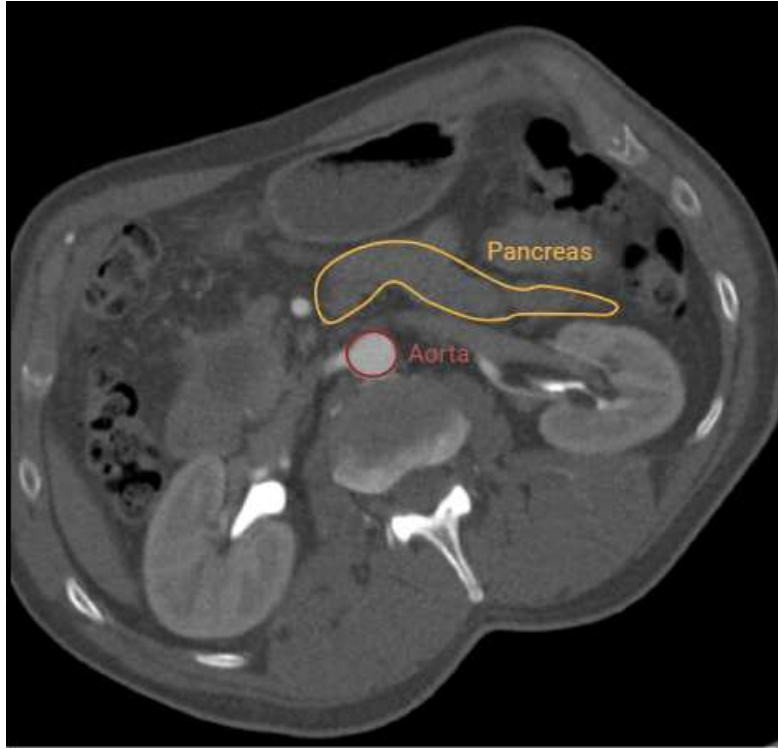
Dynamic contrast-enhanced CT (DCE-CT) images at the 1st, 15th, and 30th acquisition time-point of a single slice of a pancreatic adenocarcinoma patient
